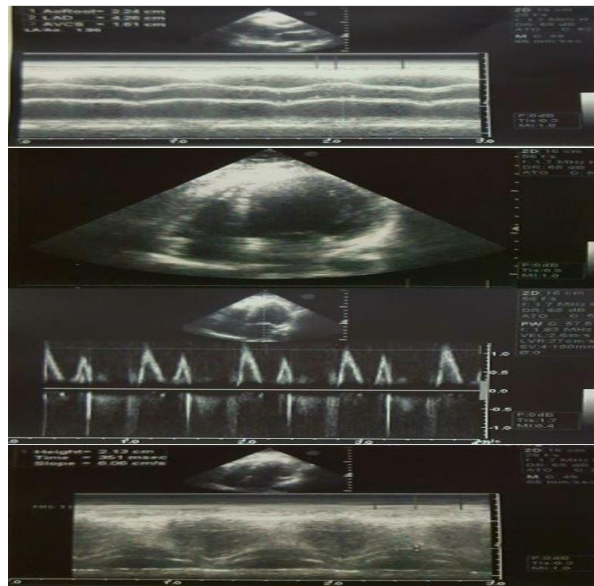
Presentation of normal left ventricular size with normal ejection fraction: 55% by echocardiography; normal size and function of the right ventricle; tricuspid annular plane systolic excursion: 1.85; observation of no valvular heart disease
